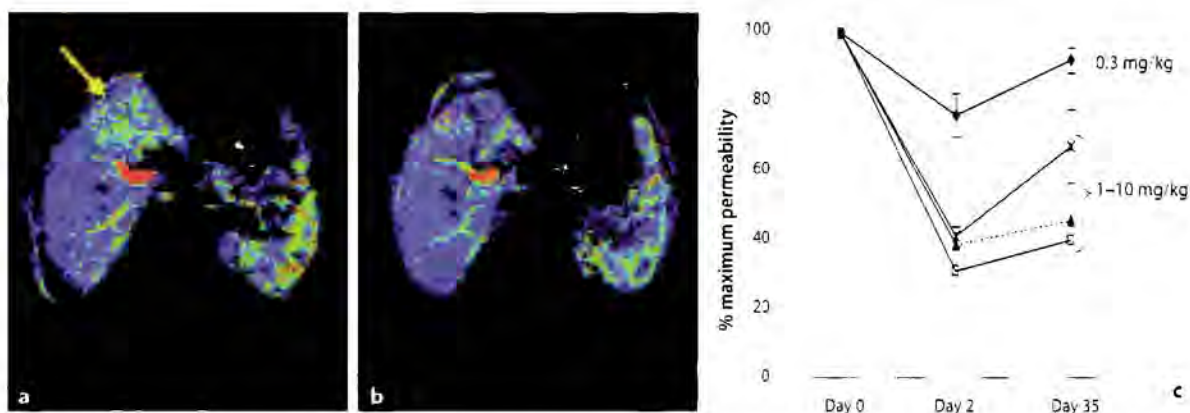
DCE-MRI map of K^{trast} in a hepatic metastasis (yellow arrow) in the left lobe of the liver, a before and b 48 h after treatment with the humanized anti-angiogenic vascular endothelial growth factor antibody HuMv833 (1 mg/kg). Green and blue areas represent high and low vascular permeability, respectively. Red and yellow pixels represent high (artefact) measurements in the hepatic vein. c The K^{trast} of representative tumours shown for all patients before treatment, 2 days after first treatment, and 35 days after the first treatment was initiated. Data expressed as the mean percentage change relative to the value before treatment for each different treatment dose level, with 95% confidence intervals. Each dose level is represented by a different symbol: diamonds, 0.3 mg/kg; squares, 1 mg/kg; triangles, 3 mg/kg; crosses, 10 mg/kg. (Reproduced from Jayson et al. 2002)
